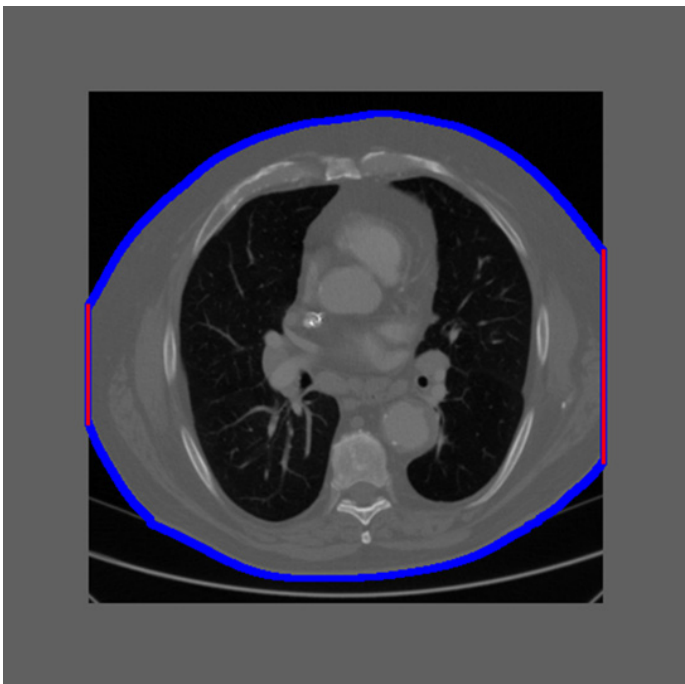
Example of an intentionally truncated CT image. The truncation percentage was calculated as the ratio of the patient border touching the field of view to the total patient border $\left(\frac{red}{red+blue}\right)$.
